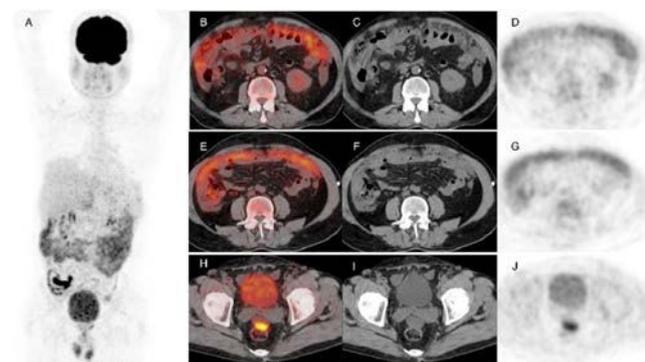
Full Body PET scan (A), Axial PET/CT images showing omental thickening and peritoneal involvement (B, E, H), Corresponding axial CT images (C, F, I), PET images highlighting FDG uptake (D, G, J) Bone marrow and omentum biopsies were performed. The bone marrow biopsy confirmed CLL/SLL.
